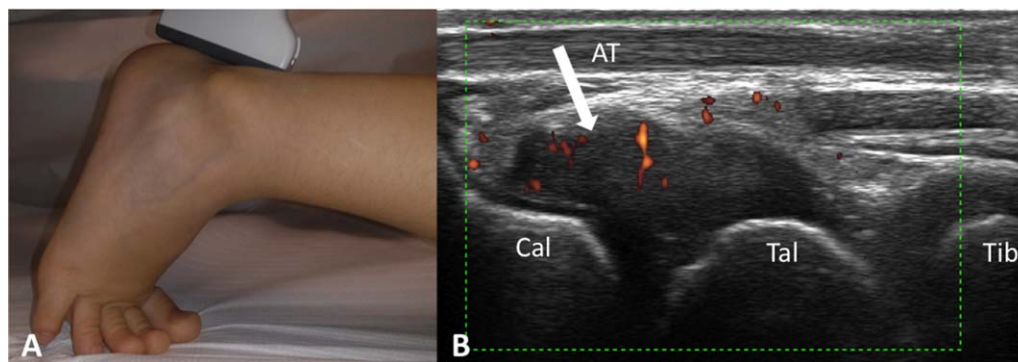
Position of the probe for the posterior scanning approach to the subtalar joint (A) and synovitis (arrow) (B) exhibiting power Doppler signal through the posterior scanning approach in a 4-year-old girl with juvenile idiopathic arthritis. Cal = calcaneus; AT = Achilles tendon; Tal = talus; Tib = tibia.
